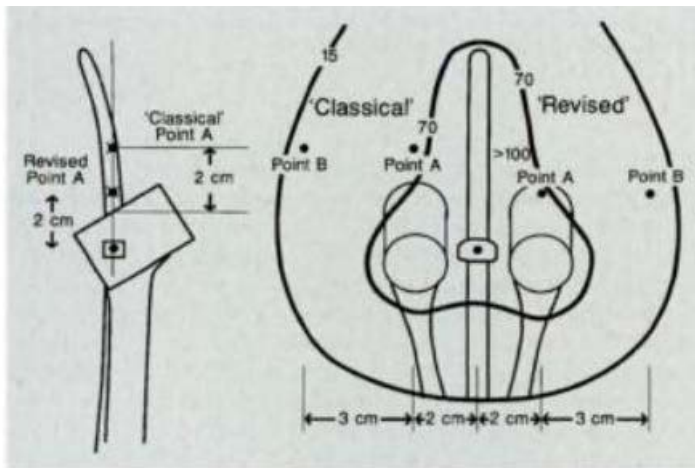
Radiographic definition of classical point A (2 cm above the cephalic-most aspect of the colpostat in the tilted coronal plane) and the revised point A (2 cm above the cervical collar top or center). Because the distance from caudal-most intrauterine source tip to colpostat center (tandem-to-colpostat displacement) varies from patient to patient, the vaginal contribution to revised point A is highly variable. (From Potish RA, Gerbi BJ. Role of point A in the era of computerized dosimetry. *Radiology* 1986;158:827-831, with permission.) The revised definition was suggested in Tod M, Meredith WJ. Treatment of cancer of the cervix uteri: A revised Manchester method. *Br J Radiol* 1953;26:252-257.
